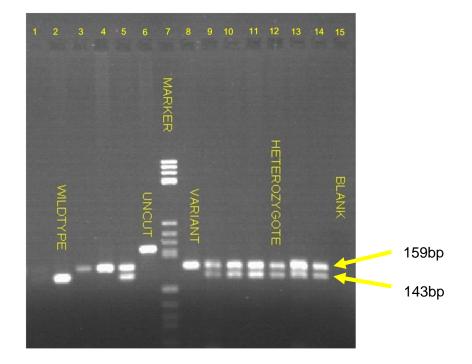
Gel image of PCR products for the ApoCIII C482T polymorphism. Lane 2= Homozygote for the wildtype CC (143bp), Lane 6= Undigested PCR product (Control), Lane 7= Molecular Marker V, Lane 8= Homozygote for the variant TT (159bp), Lane 12= Heterozygote for the variant CT (159bp+143bp) and Lane 15= Blank (Control).
